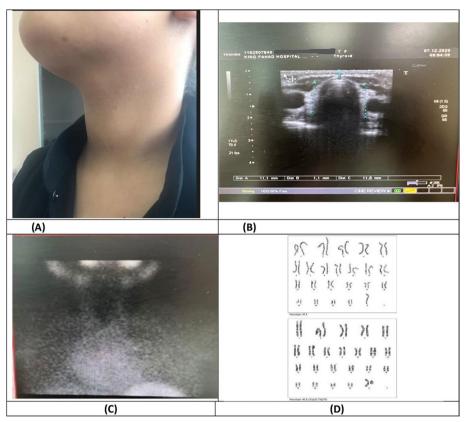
A 9-year-old girl with goitrous hypothyroidism and the genetic study revealed autosomal recessive thyroid dyshormonogenesis type 3 (A); thyroid US showed small heterogenous thyroid gland in a 7-year-old female with hypothyroidism (B); the Tc pertechnetate thyroid scintigraphy showing no evidence of functioning thyroid tissue (C); Karyotyping of a 7-year-old female presented with short stature showing 45, X (D)
